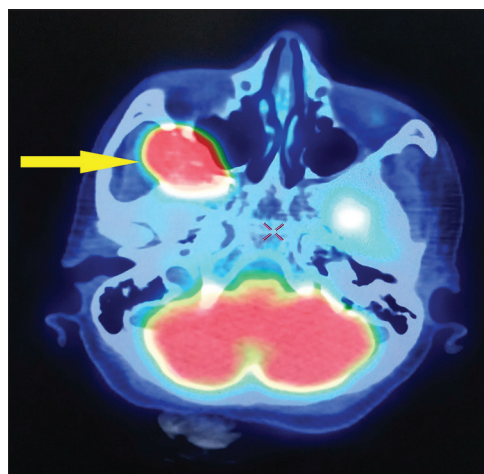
18-Fluorodeoxyglucose positron-emission computed tomography scan (fused image) showing metabolically active skeletal lesion involving sphenoid bone (yellow arrow)
